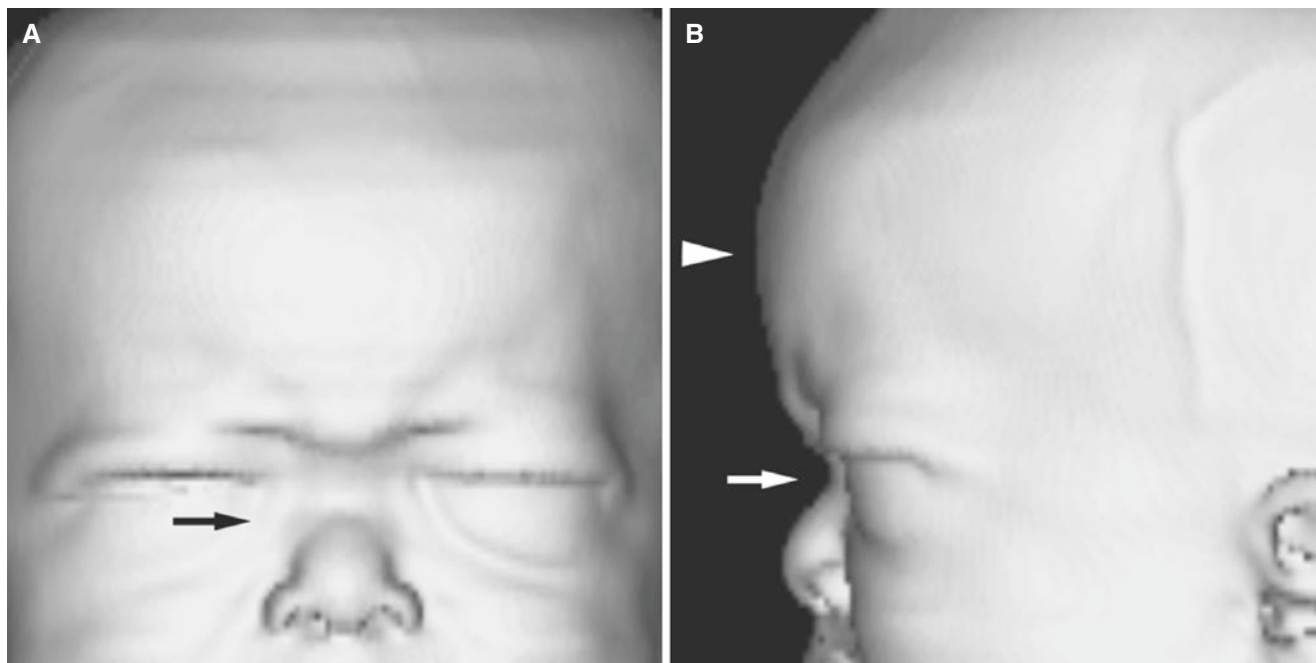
Achondroplasia; 7-month-old. (A) 3D CT image, en face view of the skin, shows saddle nose (arrow). (B) 3D CT image, lateral view of the skin, shows saddle nose (arrow) and prominent forehead
